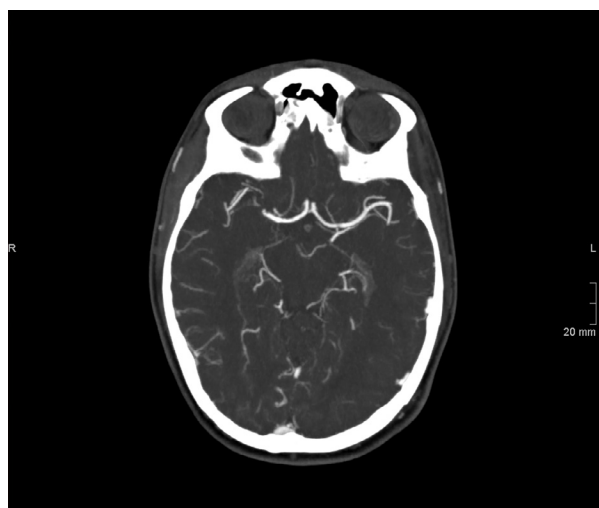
Axial CTA image at the level of the circle of Willis and both MCAs. Abbreviation: MCA, middle-cerebral-artery; CTA, CT angiogram.
